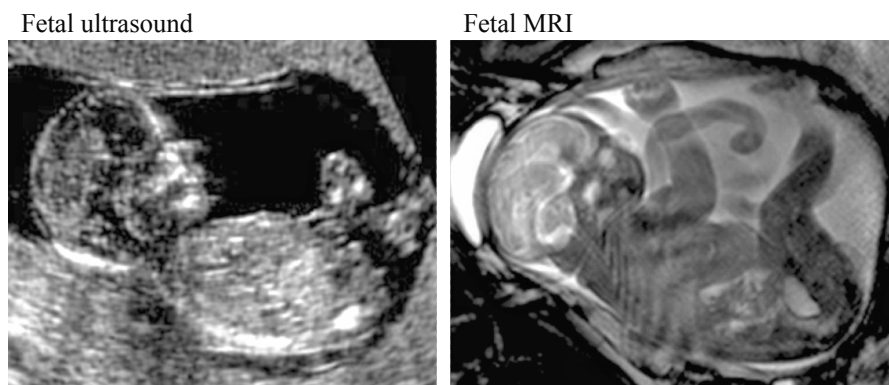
Imaging of the brain maturation before birth using ultrasound and fetal MRI.
